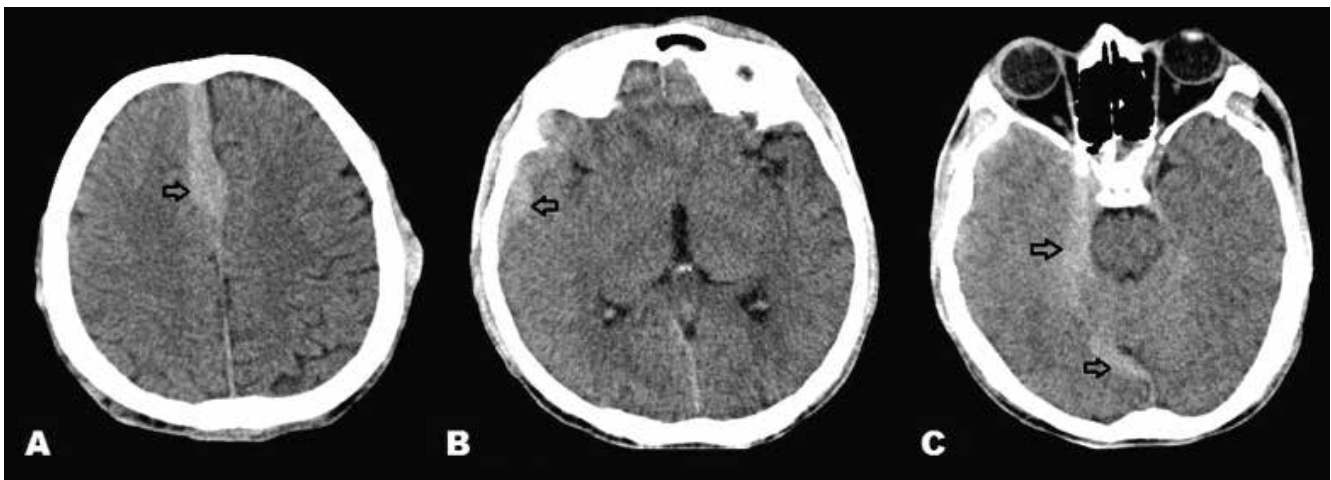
1- Multi- axial Plain CT sections of brain above the level of lateral ventricles (A), at level of quadrigeminal plate cistern (B) and at the level of pons (C), showing hyper-dense intradural nodular deposits at parietal region, sylvian fissure and at para-falcine location along the tentorium cerebelli – [black arrows].
